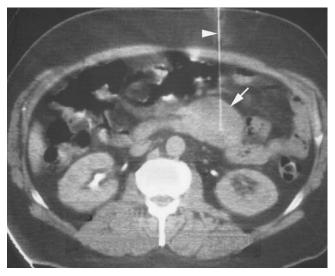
Use of computed tomography to guide fine-needle aspiration (*arrowhead*) of a mass lesion in a patient with Zollinger-Ellison syndrome. The gastrin level in the aspirate from the mass was 11,518 pg/mL (the peripheral venous gastrin level was 769 pg/mL), thus confirming it as a gastrinoma (*arrow*).
